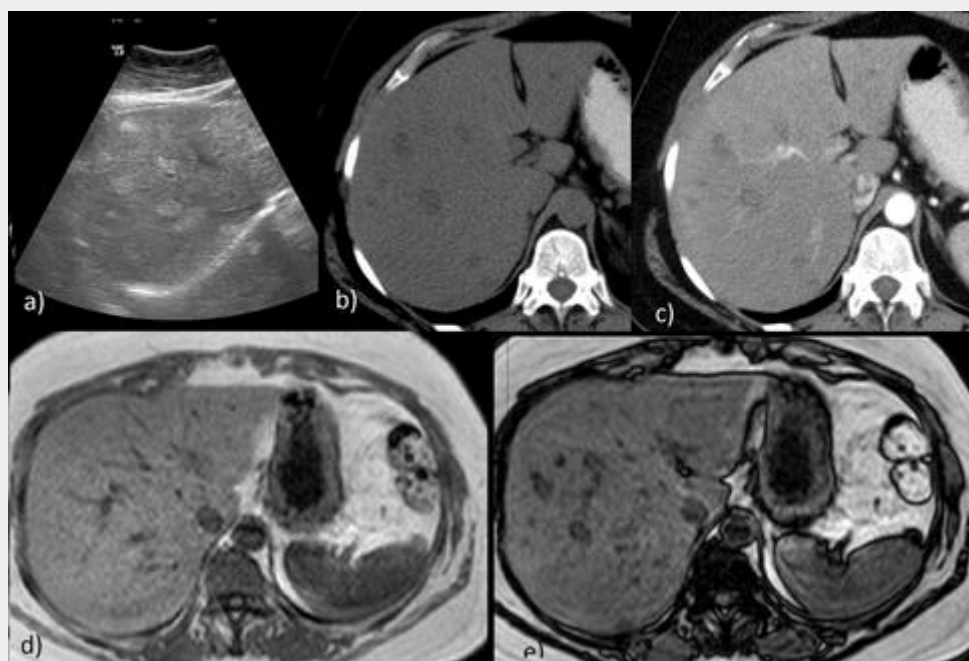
Multinodular steatosis. Ultrasound (a) shows hyper echogenic nodular lesions; in CT axial non-enhanced images there are several hypo attenuated lesions that don't enhance after contrast (b and c). In MRI T1-w out-of-phase imaging there is SI drop-off of the nodular lesions (e).
